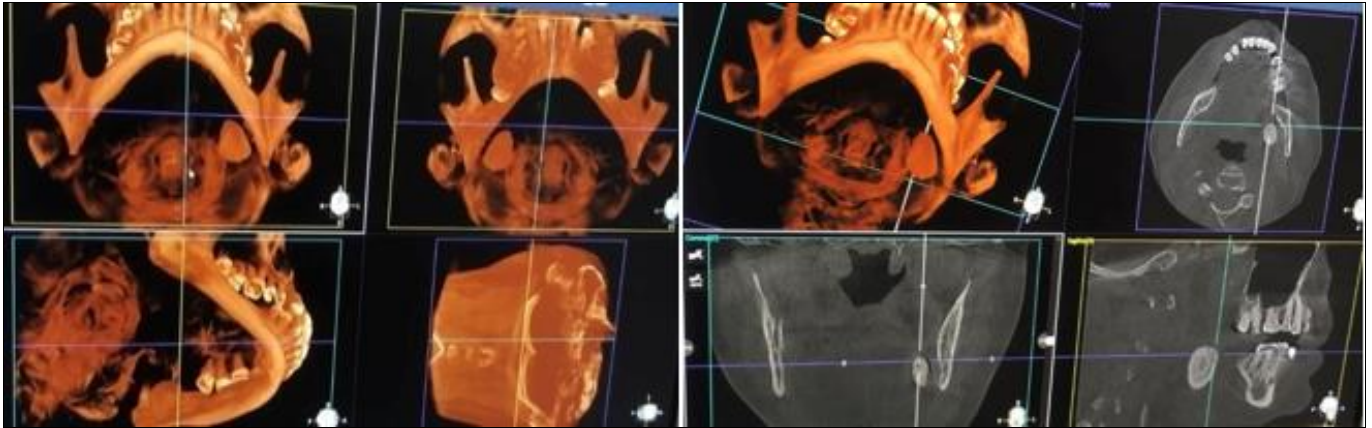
Computed Tomography scans showing a calcified mass measuring 28 mm x 17 mm
